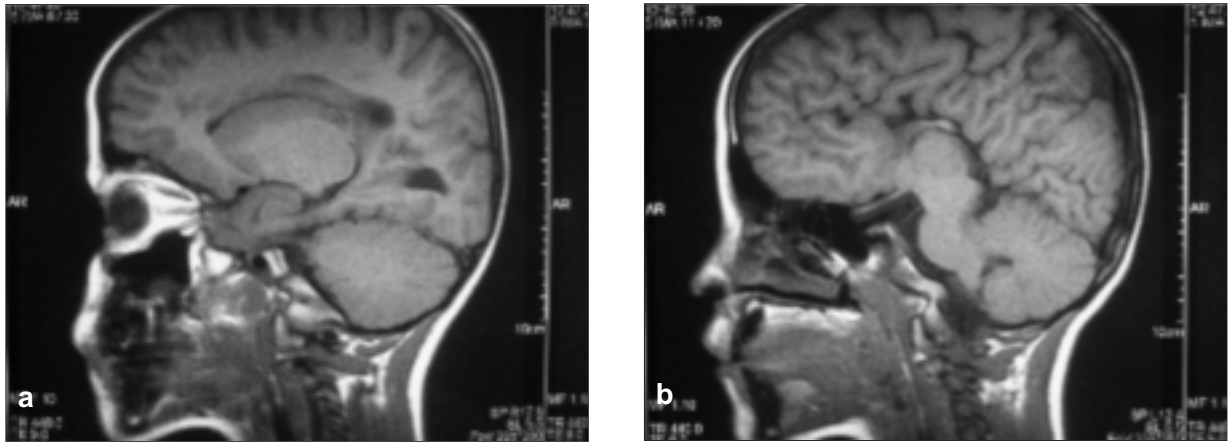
Dysgenesis of corpus callosum on magnetic resonance imaging (a,b).
